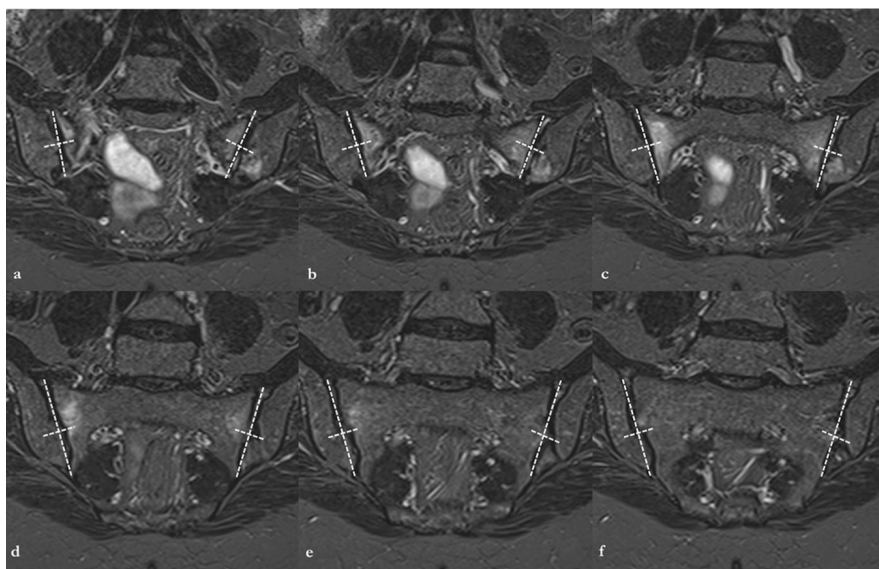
SPARCC MRI index with total score of 31, calculated in a 46-year-old woman with ankylosing spondylitis. On the selected six semi-coronal STIR images A-F: 21 points were granted for BME (example in b, 2 points for segments of the right SIJ and 3 points for segments of the left SIJ); 5 points were granted for BME depth >1 cm measured perpendicular to the articular surface (example in c, 1 point in the right sacral wing); 5 points were granted for BME intensity (example in e, 1 point in the right sacral wing).
